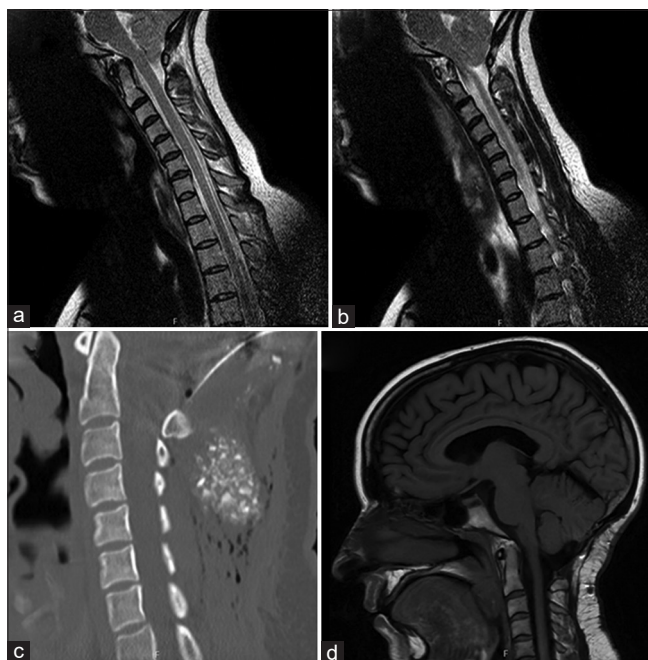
Case 2 imaging - Chiari malformation and craniocervical instability. (a and b). Preoperative T2-weighted sagittal cervical MRI demonstrating cerebellar tonsillar herniation below the ring of C1 and acute clivoaxial angle $<130^\circ$. (c) One-day postoperative sagittal cervical CT demonstrating expected postoperative changes of a SOC and O-C2 fusion. (d) Postoperative sagittal T1-weighted flair MRI brain 67 months after initial operation and 15 months after C6-7 fusion demonstrating expected postoperative changes of a SOC and O-C2 fusion. MRI: Magnetic resonance imaging, CT: Computed tomography, SOC: Suboccipital craniectomy
